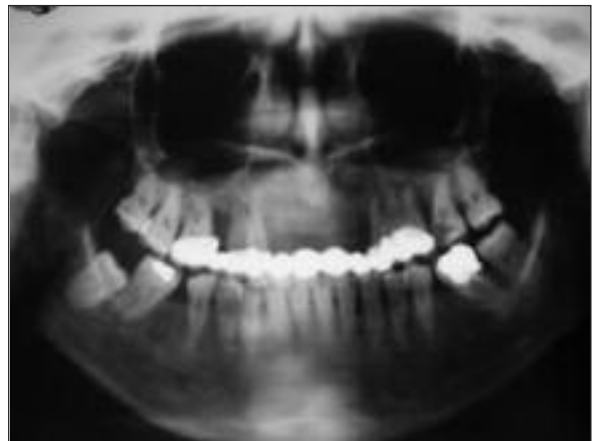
Panoramic radiography showing radioopaque foci within the tumor and radicular radiolucencies extended by occupying the roots apex.
